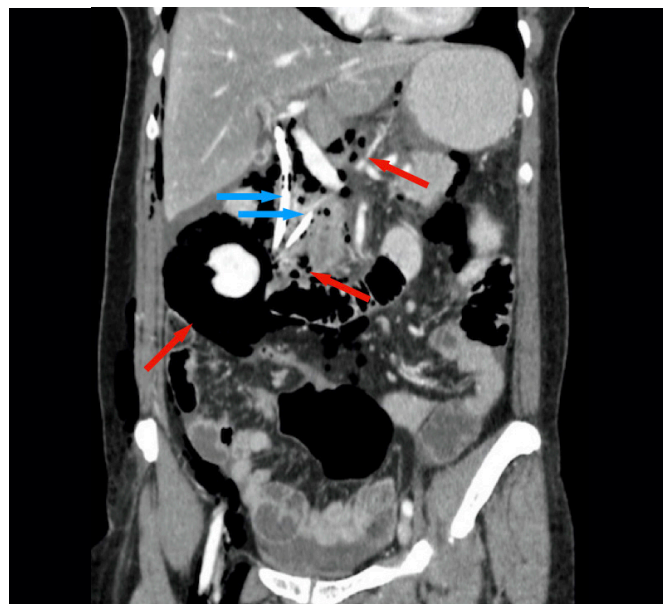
Abdominal CT obtained 1 day after endoscopic papillectomy (same patient as Figure 1). This patient had intraoperative bleeding, treated endoscopically. There is a duodenal perforation with retroperitoneum without liquid collection (red arrows). A biliary and a pancreatic plastic stent were placed, which were removed later (blue arrows). This patient underwent conservative treatment and discharge from hospital 9 days after the procedure. There were no signs of recurrence after 18 months at endoscopic follow-up.
